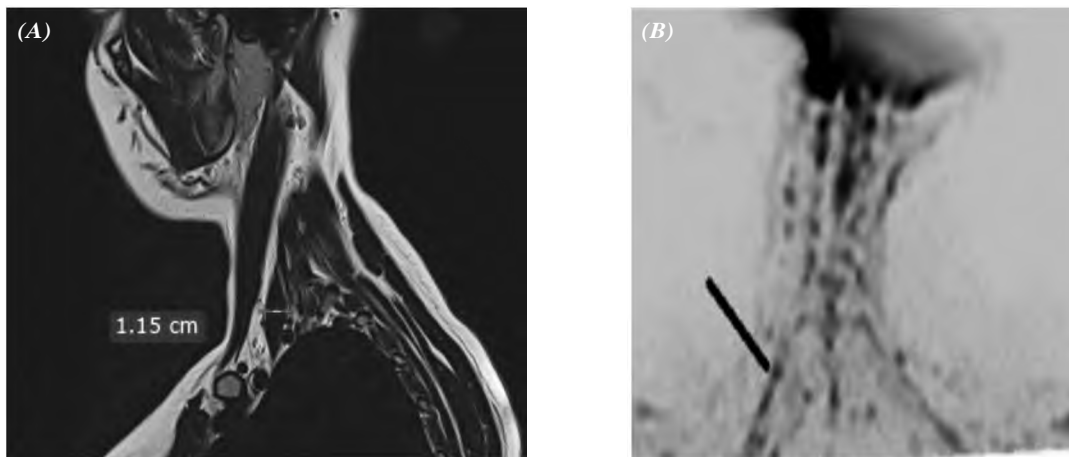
Female patient 28 years old complained from right upper limb pain of 2 years duration, (A): Sagittal T2WI showing hypertrophied anterior scalene muscle, (B): Coronal DWI showing restricted signal (edema) of the right upper trunk (black line).
